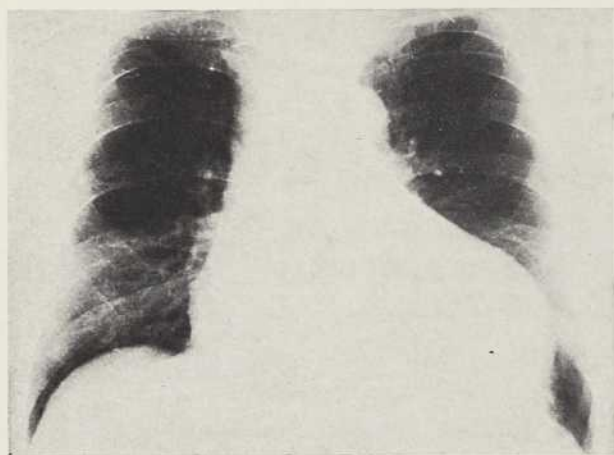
X-ray chest 16 months after operation in the second heart transplant patient (P.B.) showing the gross cardiomegaly.
